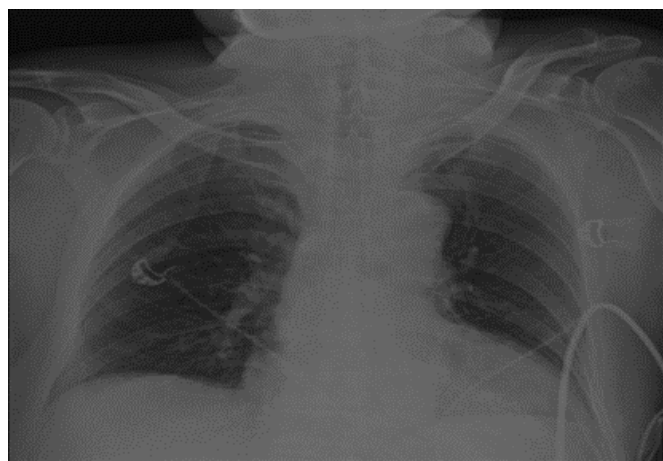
Anteroposterior chest radiograph (PA-AC)
